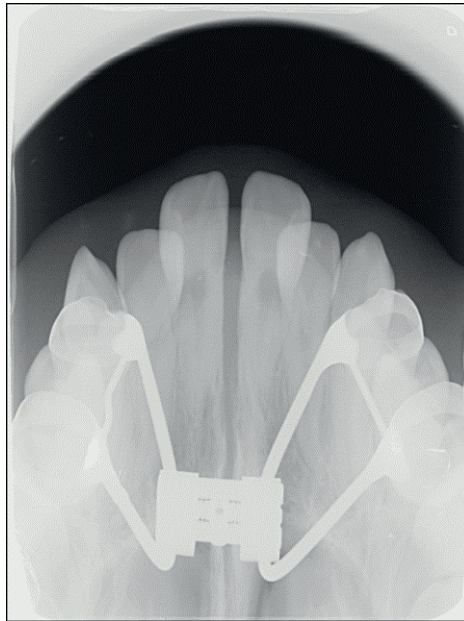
Example of occlusal radiograph
